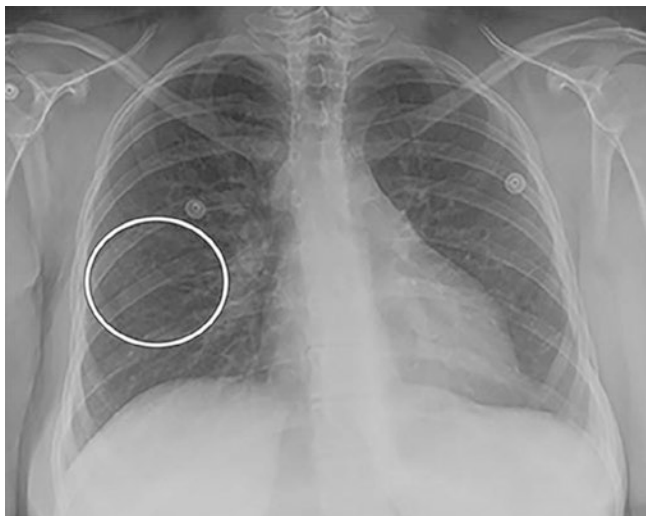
A 17-year-old girl presenting with acute onset of shortness of breath. Frontal chest radiograph demonstrates subtle decreased vascularity (white circle) in the midportion of the right lung (Westermarck sign). (Reprint with permission from Lee et al. [9])
